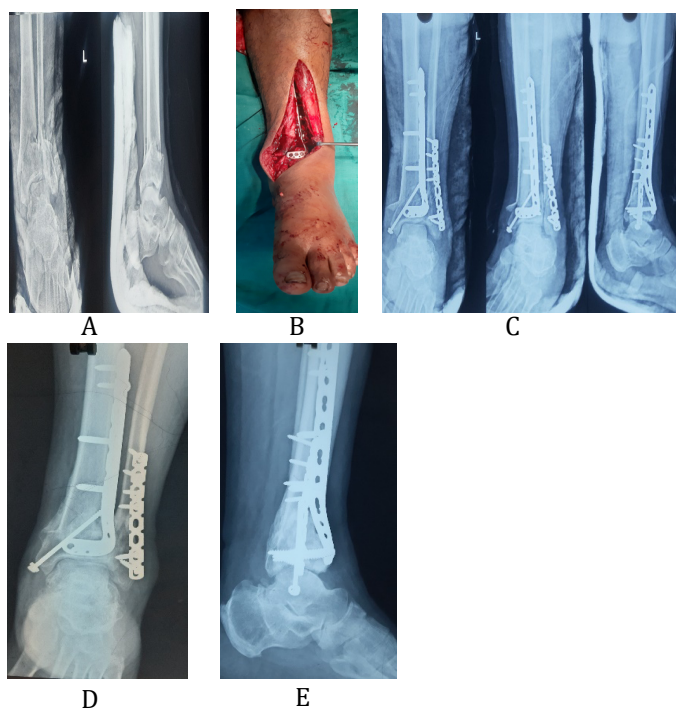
(A) Preoperative X-ray of tibial pilon fracture; (B) Anteromedial approach with anatomical anterolateral locking plate; (C) Immediate post operative X-ray; (D, E) Follow up X-ray showing union.
